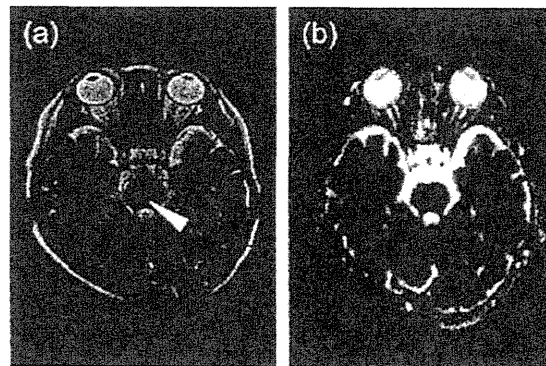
(a) Improved findings in the pons on T2-weighted images, as evidenced by the slightly hyperintense area (arrowhead). (b) ADC map showing almost normal findings.
